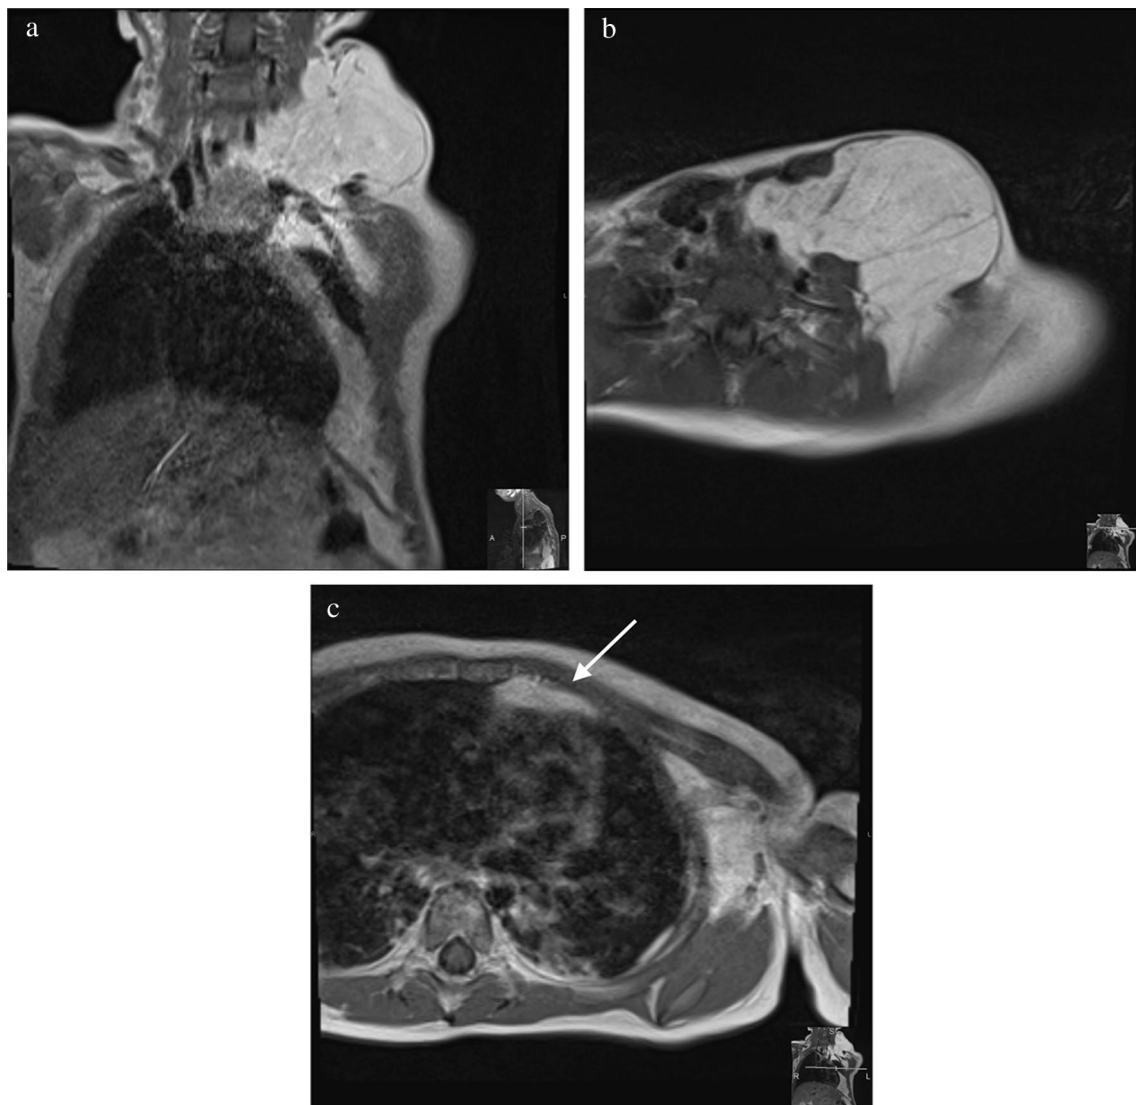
a Coronal T1 MRI Neck with contrast shows a large lobulated fat containing mass in the leftward neck extending into the mediastinum, subscapular region, and axilla. b Axial T1 MRI Neck with contrast shows a large lobulated fat containing mass in the leftward neck extending into the mediastinum, subscapular region, and axilla. c Axial T1 MRI Neck with contrast shows a large lobulated fat containing mass in the leftward neck extending into the mediastinum (white arrow), subscapular region, and axilla
